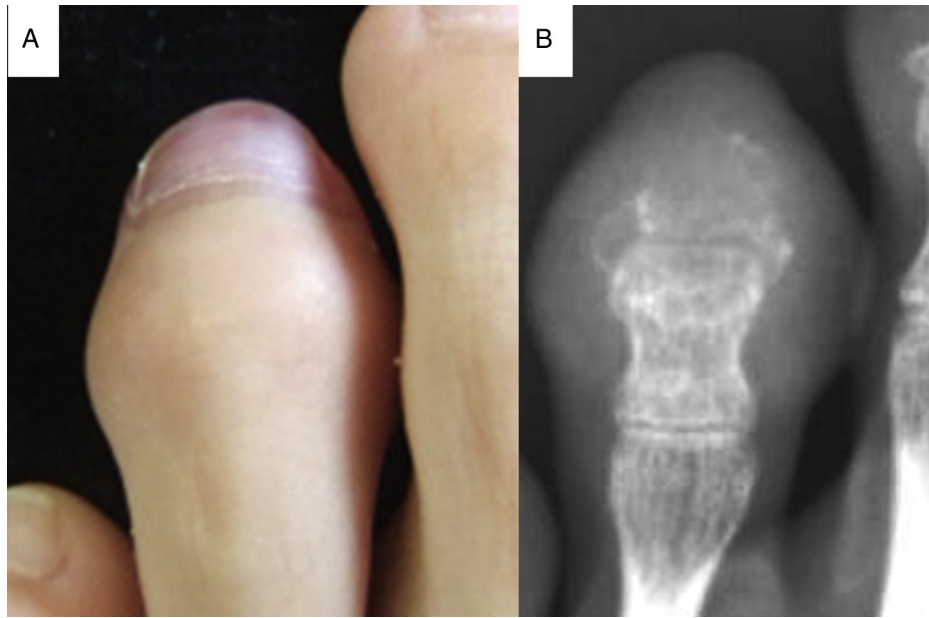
(A) Clinical photograph showing enlargement of the toe and toenail in the distal part of the patient's fourth toe. (B) Anteroposterior radiograph of the distal phalanx of the fourth toe at initial presentation showing osteolysis with cortical destruction.
